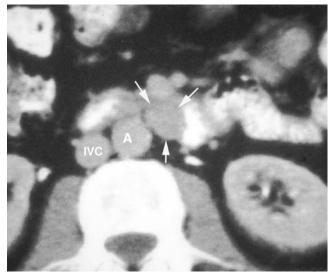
Computed tomographic appearance of a gastrinoma (*arrows*). The identification of the tumor is facilitated by the presence of contrast material in the small bowel adjacent to the lesion. No intravenous contrast is seen in the inferior vena cava (IVC) or aorta (A).
